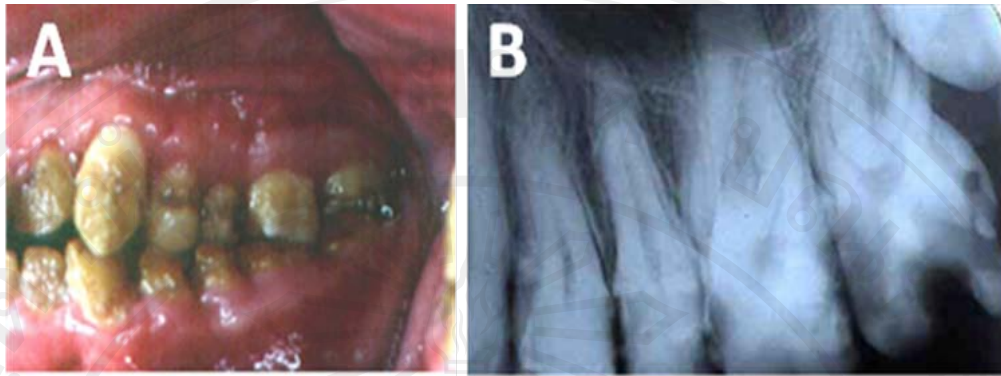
(A) The clinical manifestation showed generalized hypoplastic enamel with some horizontal and vertical grooves on enamel. (B) The radiographic examination shows dilaceration in normal-sized root tooth (Gutierrez et al., 2007).
